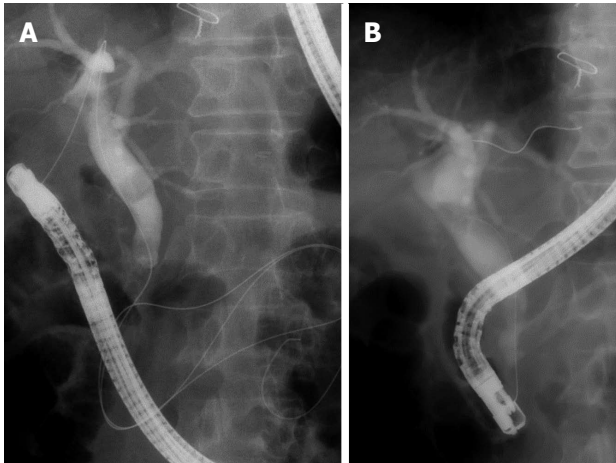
Images of a rendezvous technique via the endoscopic ultrasound-guided choledochoduodenostomy fistula. A: The common bile duct was cannulated via the EUS-CDS fistula and a guidewire was advanced into the duodenum through the papilla; B: The guidewire was caught in the duodenum and transpapillary biliary cannulation was succeeded.
